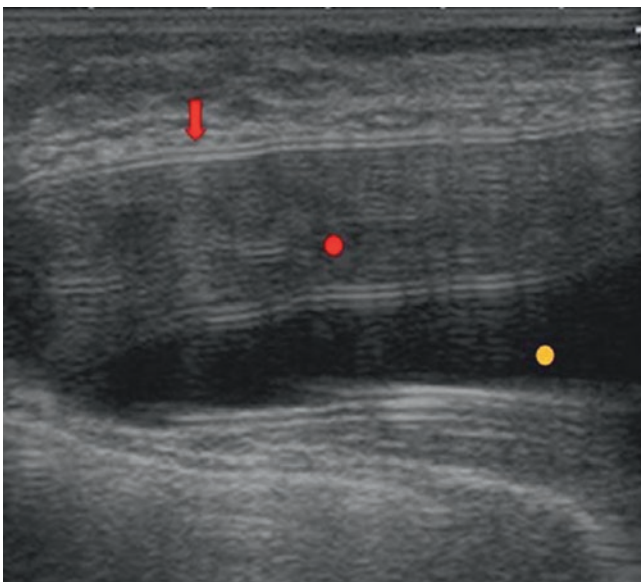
Ultrasound appearance of a silicone gel implant: Oval and anechoic mass where the elastomer appears as double hyperechoic line (*red arrow*) with reverberation artifact below (*red dot*), and the silicone gel shows an anechoic appearance (*yellow dot*). There is no filling valve. This image appeared in the *European Aesthetic Plastic Surgery Journal* (number 12). Reproduced with permission from the *Asociación Española de Cirugía Estética Plástica*.
